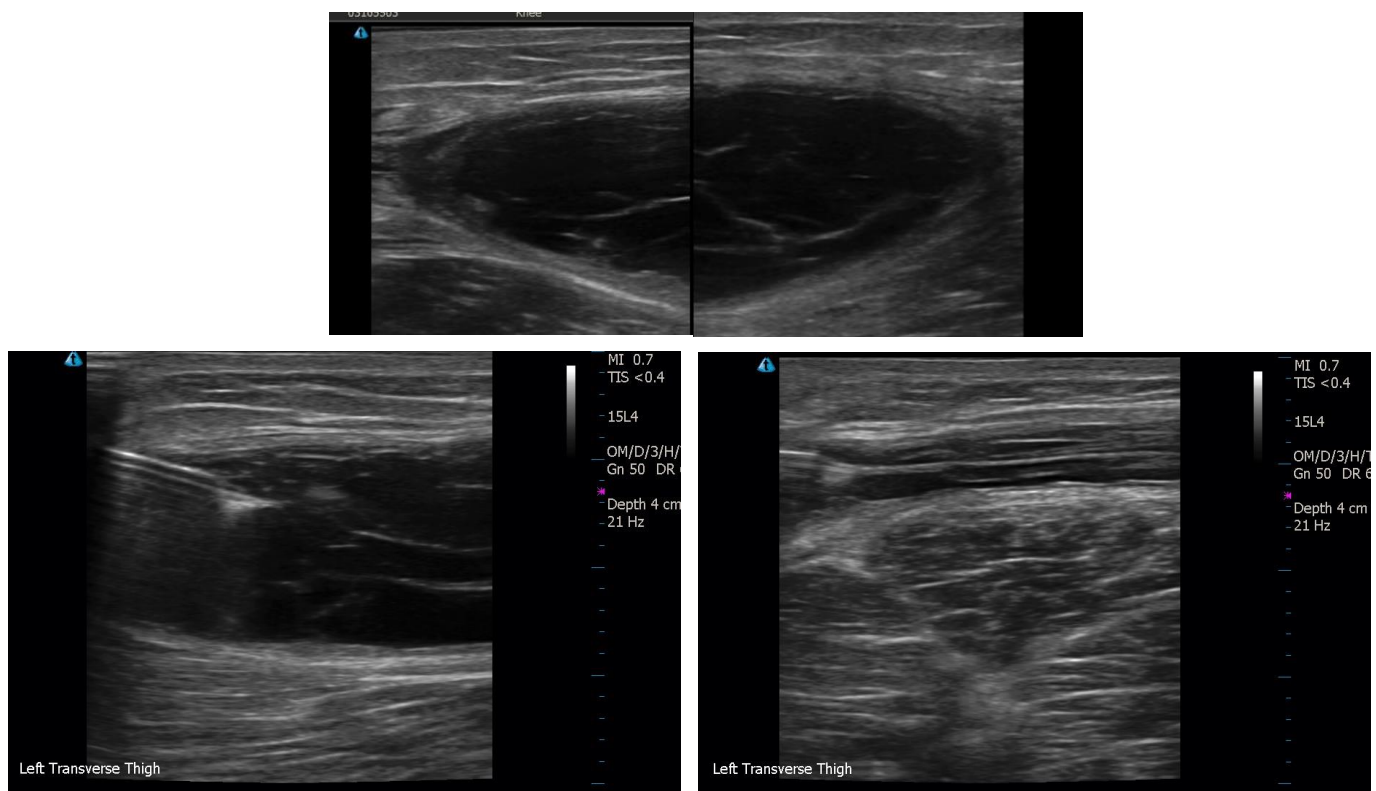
Patient 4 A: Axial sonography of lesion pre-aspiration. B: Longitudinal oblique image during aspiration. C: Longitudinal oblique at the end of aspiration.
